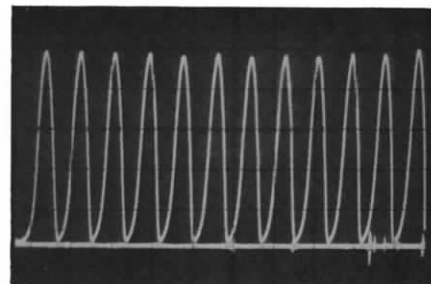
Normal single-phase x-ray output waveform
